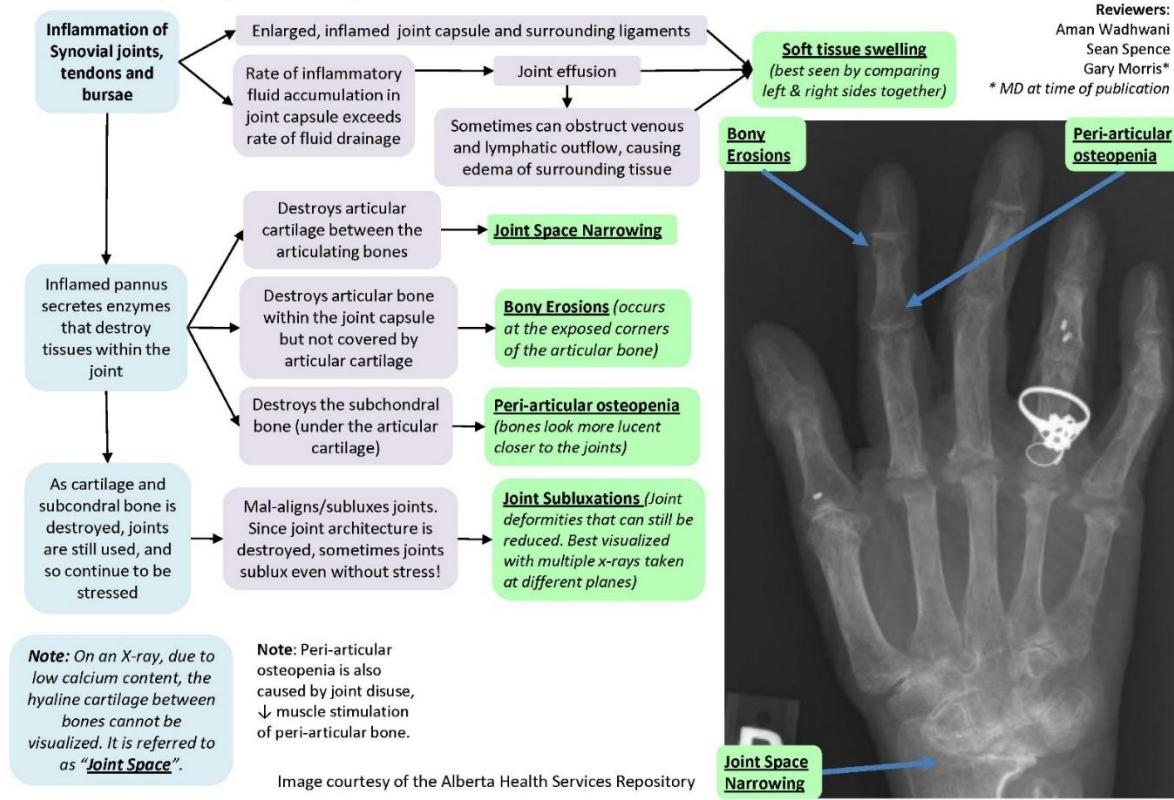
RA, findings on X-ray.⁴
